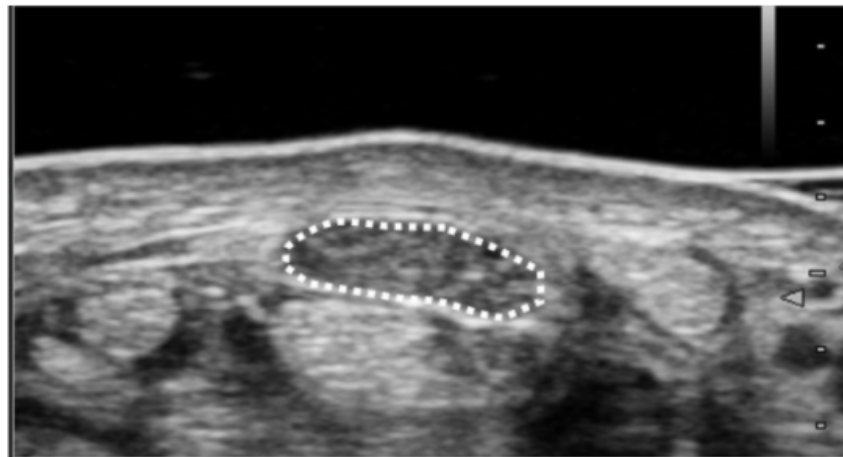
Ultrasound measurement of median nerve cross-sectional area. Cross-sectional area was measured as the only parameter for the image analysis. Measurement of the median nerve cross-sectional area was performed at the wrist crease level. The median nerve was outlined, and its area was calculated.
